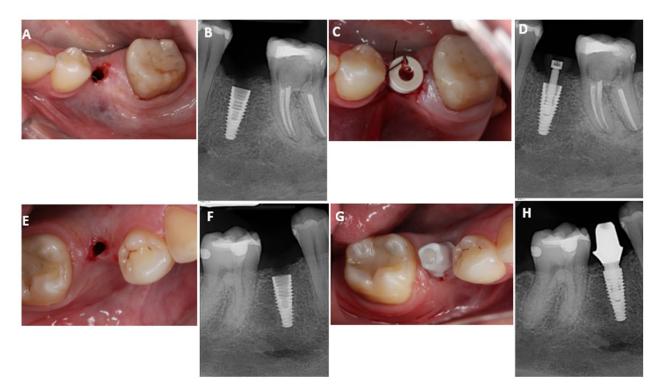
A) to D) Immediate clinical and radiographic conditions after implants and abutments insertion on region 35. E) to H) Immediate clinical and radiographic conditions after implants and abutments insertion on region 45.
